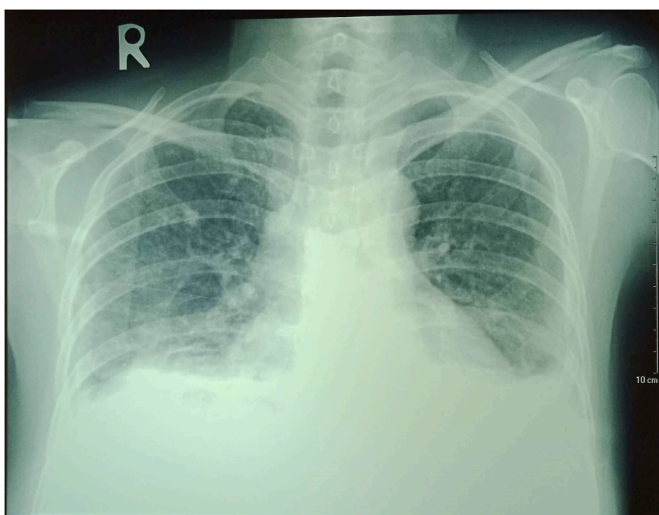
Chest X-ray showing bilateral pleural effusion in lungs.
